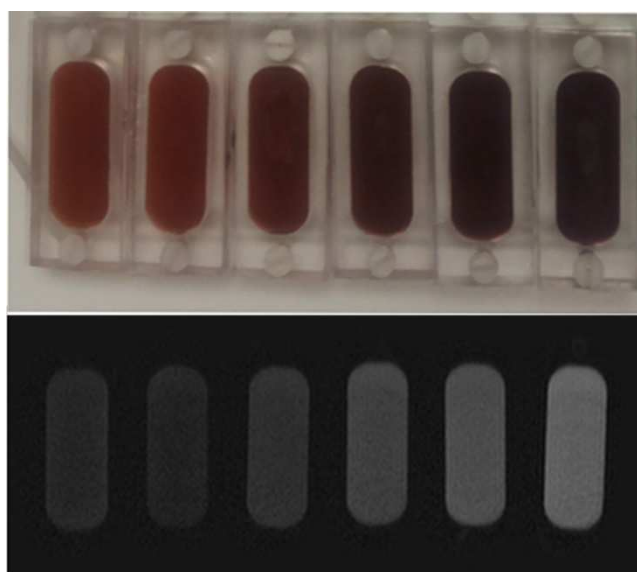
(above) Picture of FXG irradiated in the clinical range (1.75 mM); (below) MRI image obtained with IR sequence ($T_R=400\text{ms}$ and $T_I=2500\text{ms}$). Dose increases from left to right.
